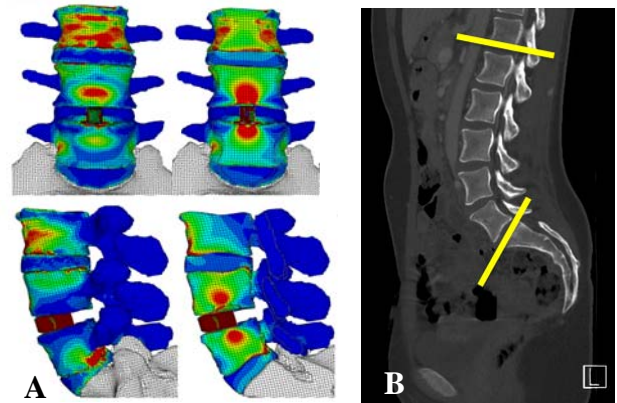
A) One possible solution for fusion device placement in both (up) anterior and (down) lateral views. B) Patient's standing X-ray with in yellow the lordosis angle
